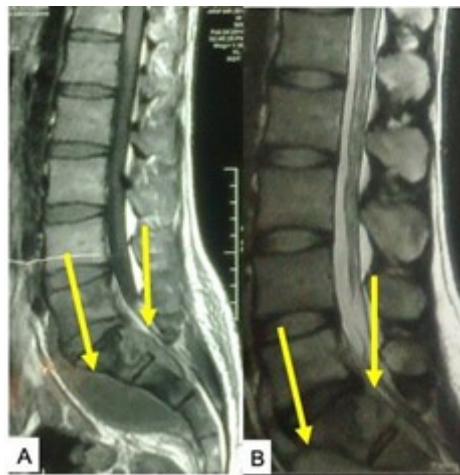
(A,B) MRI of lumbosacral spine showing lumbar spondylodiscitis (pyogenic) with epidural and presacral abscess (arrow marked). Source: Figure by authors.
